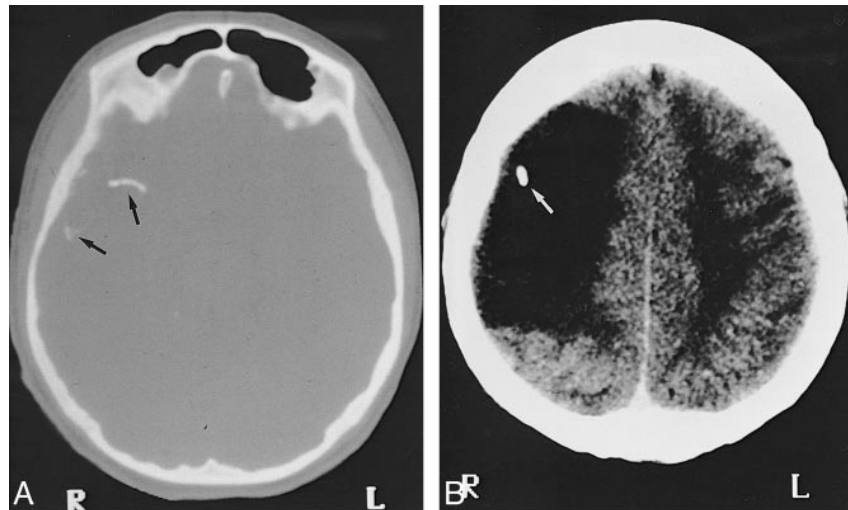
Case 2: 18-year-old boy with large juvenile nasopharyngeal angiofibroma on the left side. Axial CT scan of the orbits with bone windows shows Histoacryl in the left ophthalmic artery (arrows).
